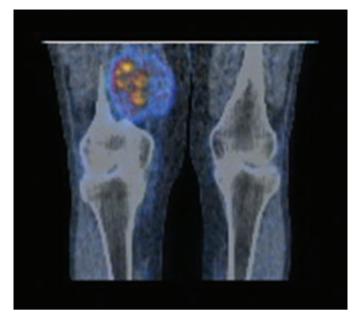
PET-CT scan showing increased uptake in a leiomyosarcoma of the right thigh
